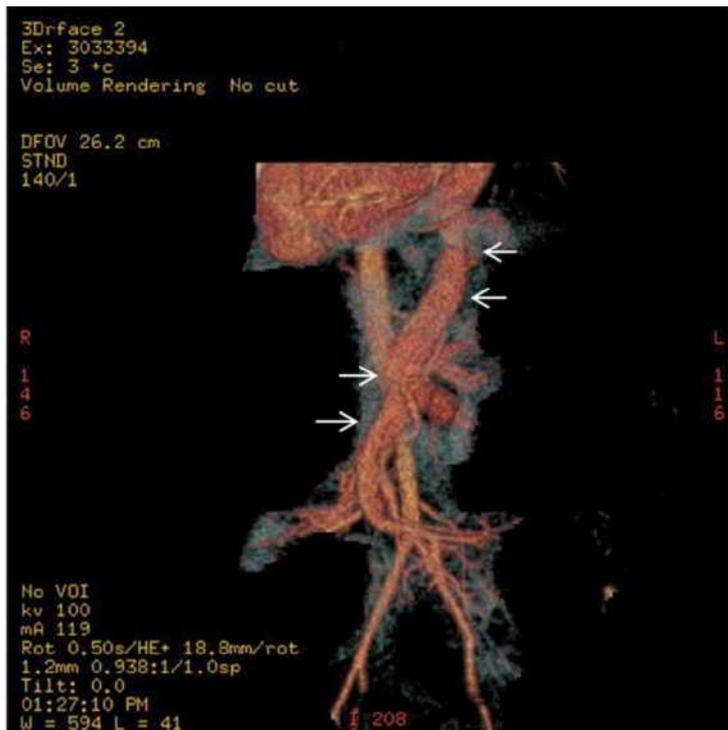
Three-dimensional CT reconstruction showing abnormal vessel that represents a congenital portosystemic shunt (arrows) draining from the portal circulation to the base of the atrium; this vessel is not connected with the pulmonary venous system.
